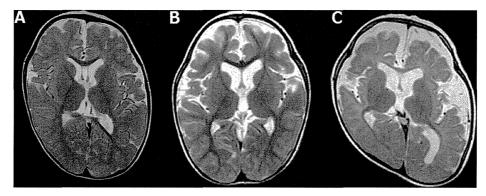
MRI findings of the three patients. (A): T2WI MRI in Patient 1 (12 months of age) showing mild brain atrophy, large cavum septi pellucidi and cavum vergae. (B): T2WI MRI in Patient 2 (18 months of age) with remarkable atrophy of bilateral frontal lobes. (C): T2WI MRI in Patient 3 (12 months of age) showing hypoplastic corpus callosum, severe bilateral diffuse atrophy and possible delay of myelination.
